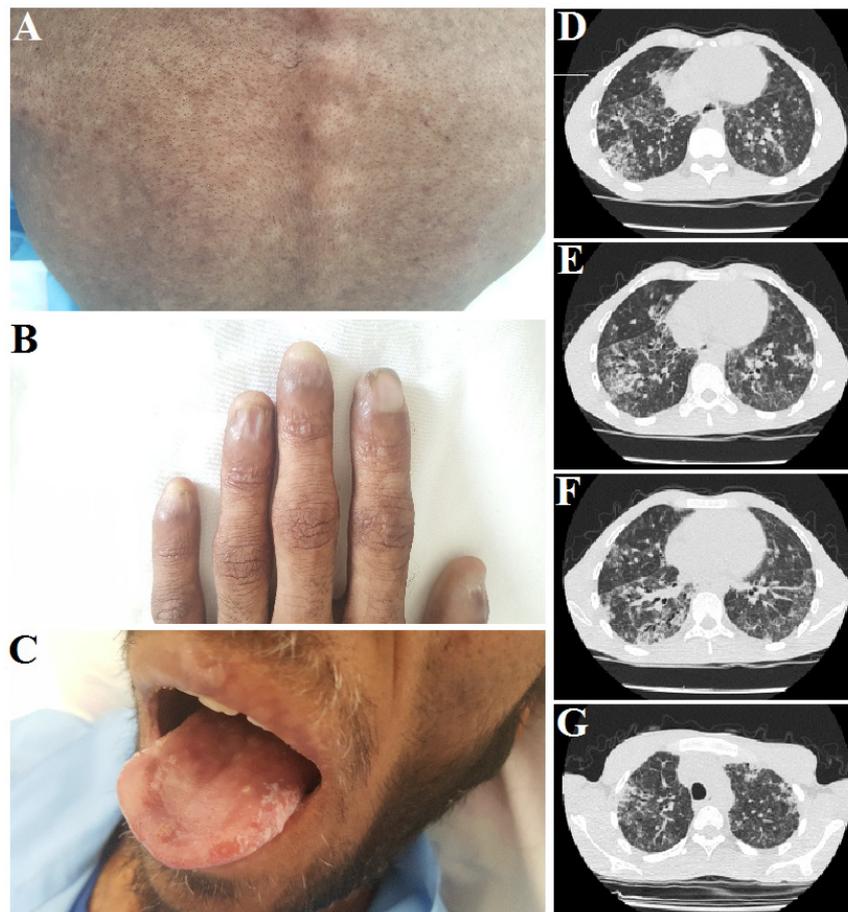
A) Cutaneous examination revealed hyper-pigmented and hypo-pigmented macules in a reticulated pattern all over the skin, especially in upper trunk. B) Nail dystrophy and pterygium. C) Tongue was eroded, with marginal small white irregular patches (leukoplakia). D, E, F and G) Computed tomography (CT) of his chest revealed inter lobular septal thickenings in both lungs' peripheral sites as 'honey combing' pattern which is consistent with pulmonary fibrosis.
